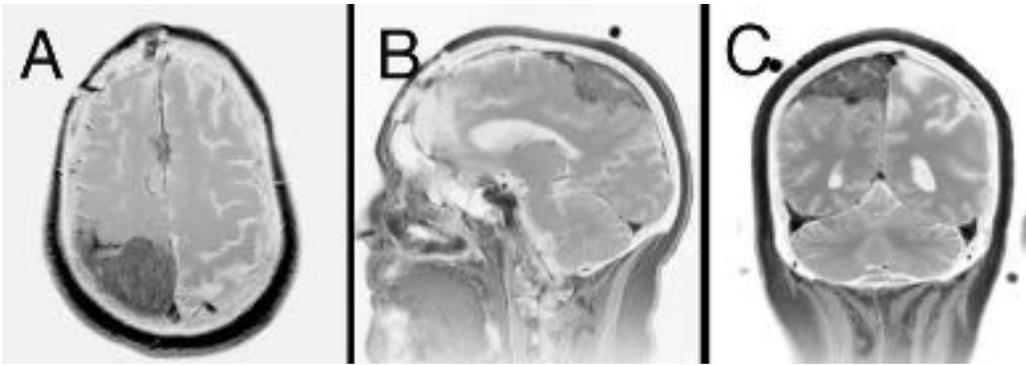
This 62-year-old female diagnosed 18 months before admission with multiple anaplastic meningiomas—one of which was resected and six were treated with radiation therapy. She returned with left-sided arm and leg weakness and intractable simple partial seizures. (A) Post-operative axial, (B) sagittal, and (C) coronal magnetic resonance imaging revealed a new $6 \times 6 \times 4$ cm right parietal meningioma abutting the central sulcus, with invasion of the brain and superior sagittal sinus.
